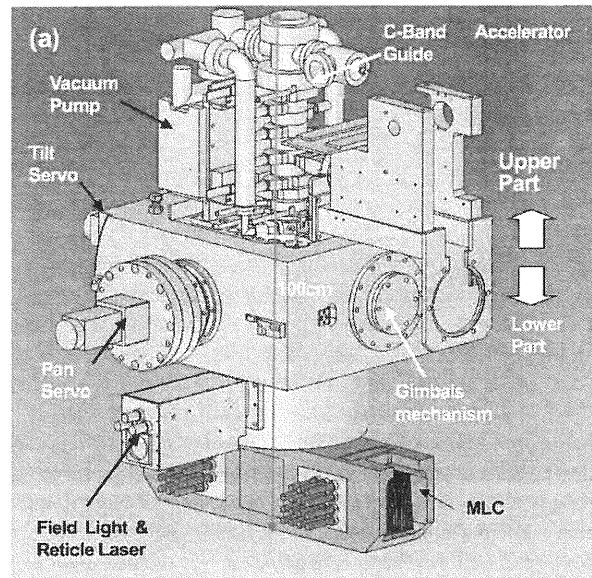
(a) The gimbaled X-ray head is mainly composed of a C-band accelerator guide, multileaf collimator, and gimbals mechanism. The center of gravity is designed to be at the gimbals axes and the inertia around the gimbals axes is minimized. (b) The upper part of the gimbaled X-ray head is shown. The C-band accelerator guide is situated on the gimbals mechanism.
